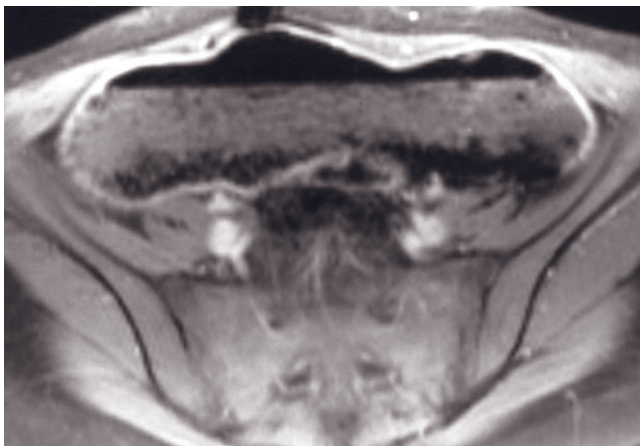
(*Continued*) superimposed on a chronically thickened wall. Coronal T2-weighted single-shot echo-train spin-echo (*d*), coronal T2-weighted true-FISP (*e*), and coronal T1-weighted fat-suppressed postgadolinium interstitial-phase 3D-GE (*f*, *g*) images demonstrate acute on chronic Crohn disease in another patient. The cecum (black arrows, *d*-*g*) is retracted because of fibrosis, and its thickened wall shows progressive enhancement due to fibrosis and inflammation. The wall of the terminal ileum is also thickened and shows increased enhancement (white arrows, *e*, *f*). Free fluid is also detected in the right lower quadrant. The presence of retracted fibrotic cecum, and thickened and enhancing terminal ileum in combination with free fluid suggests the diagnosis of acute on chronic Crohn disease.
